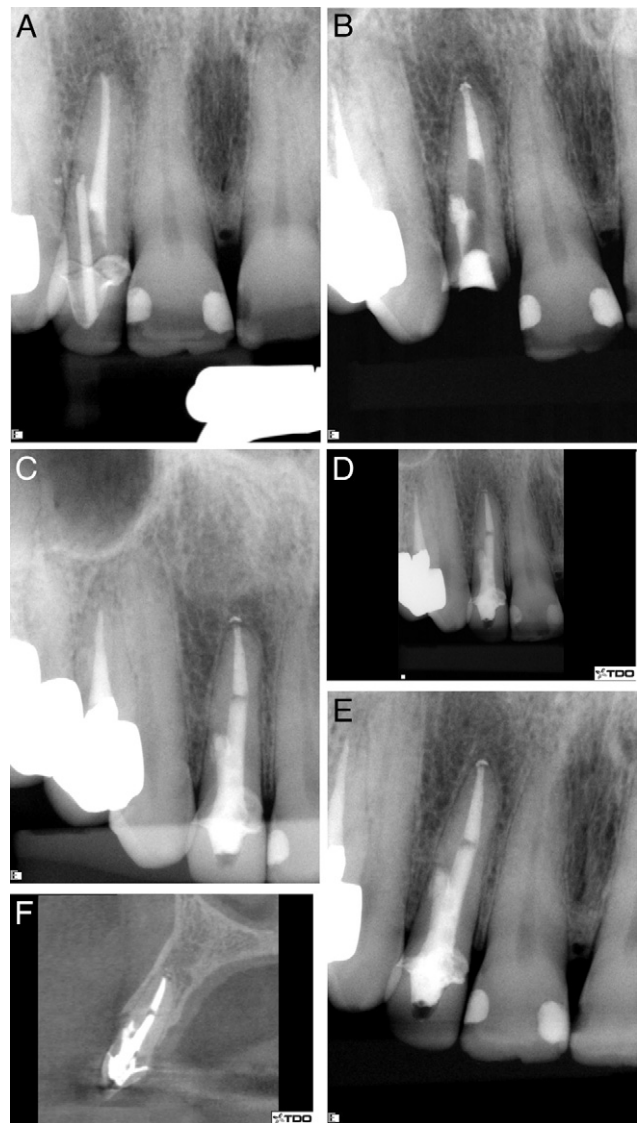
(A) A preoperative radiograph of tooth #7. The patient's symptoms and preoperative radiographs were suggestive of a perforation. (B) After disassembly, the perforation was visualized and cleaned and repaired with MTA. (C) After completion of endodontic procedures, a post and buildup were placed. The patient was held in a temporary crown for 3 months for observation and then restored with a ceramic crown. (D) At the 6-year recall, the patient was asymptomatic with normal function on tooth #7. (E) At the 13-year recall, the patient was asymptomatic and continued to function normally. (F) At the 13-year recall, cone-beam computed tomographic imaging showed soft-tissue coverage of the perforation site and no evidence of endodontic disease. A sagittal slice is shown.
